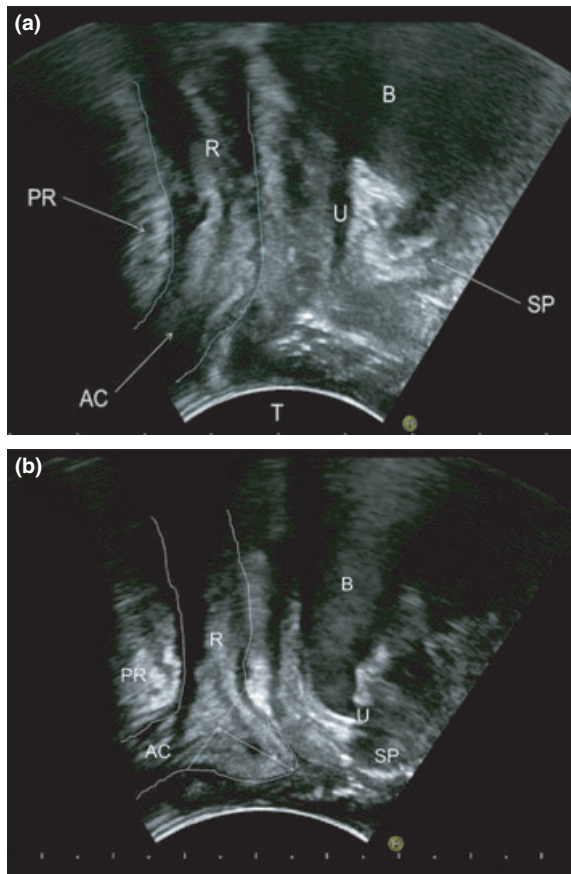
Mid-sagittal image of the pelvic floor on transperineal ultrasonography. (a) At rest. (b) During Valsalva manoeuvre. Rectocele is measured as the maximal depth of the protrusion beyond the expected margin of the normal anterior rectal wall. AC, anal canal; B, bladder; PR, puborectalis muscle; R, rectum; SP, symphysis pubis; T, convex transducer; U, urethra.
